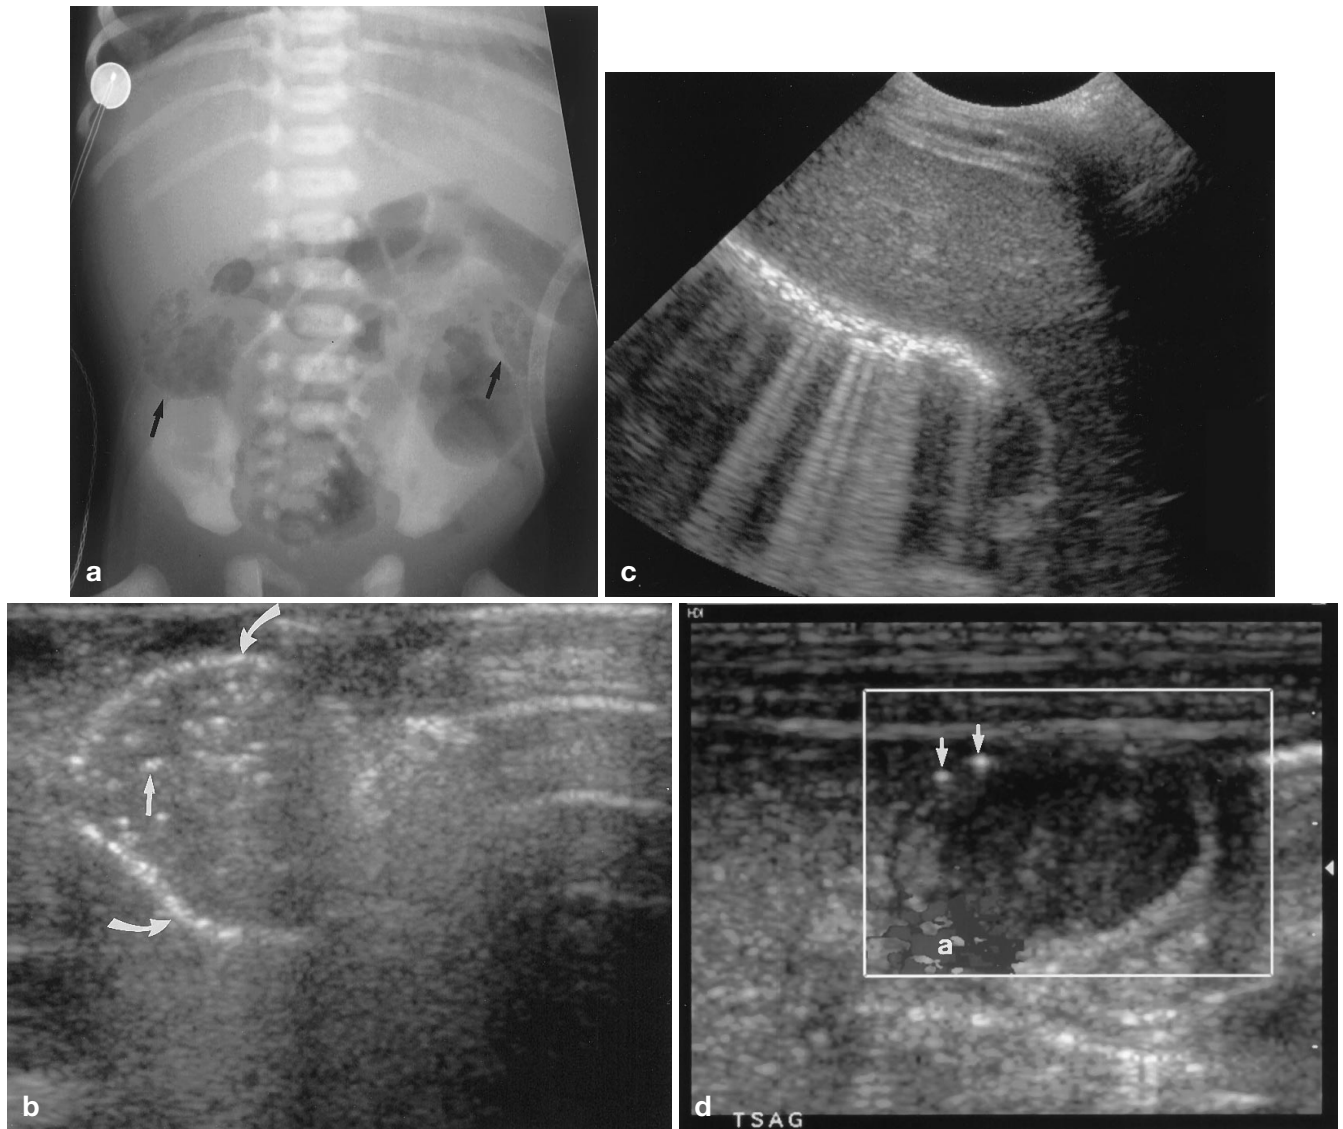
a Full-term infant with DiGeorge's syndrome, truncus arteriosus, and pneumatosis intestinalis. Radiograph demonstrates a bubbly appearance in the right and left abdomen compatible with pneumatosis (*arrows*). Bowel distension is also seen without evidence for portal venous gas. b High-resolution US during the patient's first episode of grossly bloody stool demonstrates the "circle sign" of pneumatosis intestinalis in a dilated loop of small bowel. The intraluminal gas bubbles (*straight arrow*) moved with compression, while the coarse bright echoes in the wall (*curved arrow*) did not. c Transverse US scan through the lower aspect of the liver demonstrates the "aurora sign" of pneumatosis. This shows alternating stripes of bright echoes separated by acoustic shadows and is seen only with a solid acoustic window such as liver. d Color US shown in black and white obtained 10 days after the resolution of the first episode of gross pneumatosis shows a very different appearance on US. On this examination, only two air bubbles (*arrows*) within the wall of a loop of small bowel were seen. These bubbles did not move with compression and were very different in appearance from intraluminal contents. No color flow was seen in the wall. Artificial "color" was seen from flash artifact (*a*). The cecum (not shown) was thick-walled
